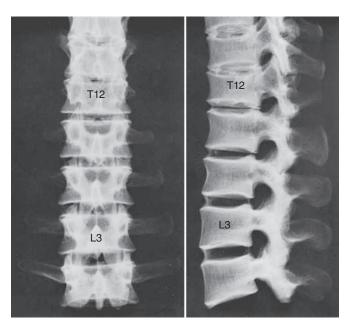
Anteroposterior (*left*) and lateral (*right*) radiographs of lower thoracic and upper lumbar region of articulated dried preparation.
